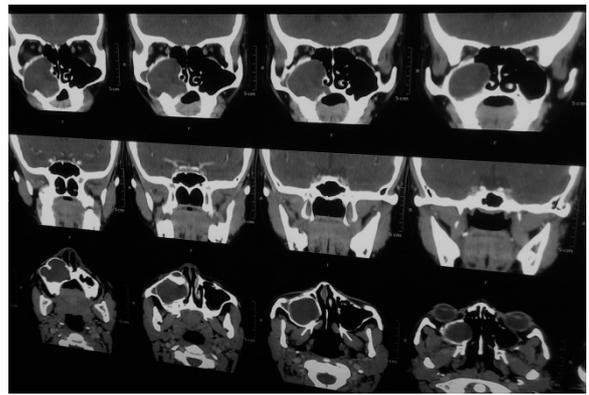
Preoperative 2D CT Scan
